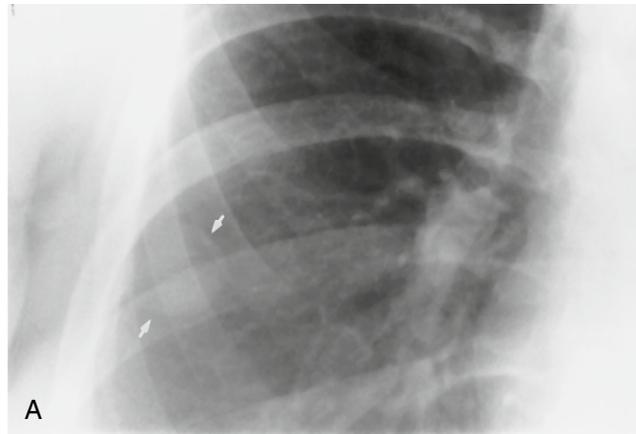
Histoplasmosis. (A) PA chest radiograph coned to the right mid lung demonstrates a sharply margined spherical opacity (arrows) adjacent to the pleura. No internal calcifications or cavitations are identified. (B,C) Thin-section, contrast-enhanced chest CT images reveal calcifications within the mass (arrows), creating a “target” appearance surrounded by curvilinear lamellar calcifications. Note enlarged hilar right hilar and subcarinal lymph nodes which also contain calcifications (arrows).
